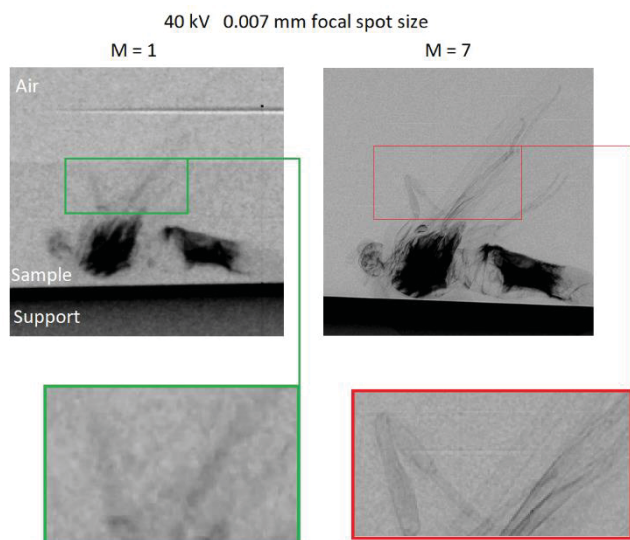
(Left) Contact radiograph (image magnification factor $M = 1.01$, $R_1 = 715$ mm, $R_2 = 9$ mm) of a moth (a common flying insect, less than 2 cm long), taken at 40 kV with a high resolution flat panel detector (50 μm pixel pitch) and a microfocus X-ray tube with a 7 μm focal spot size. The low attenuation ($I/I_0 < 0.01$) gives low contrast for the thinnest body part, as for the wings shown in the zoomed image of the bottom panel. (Right)
